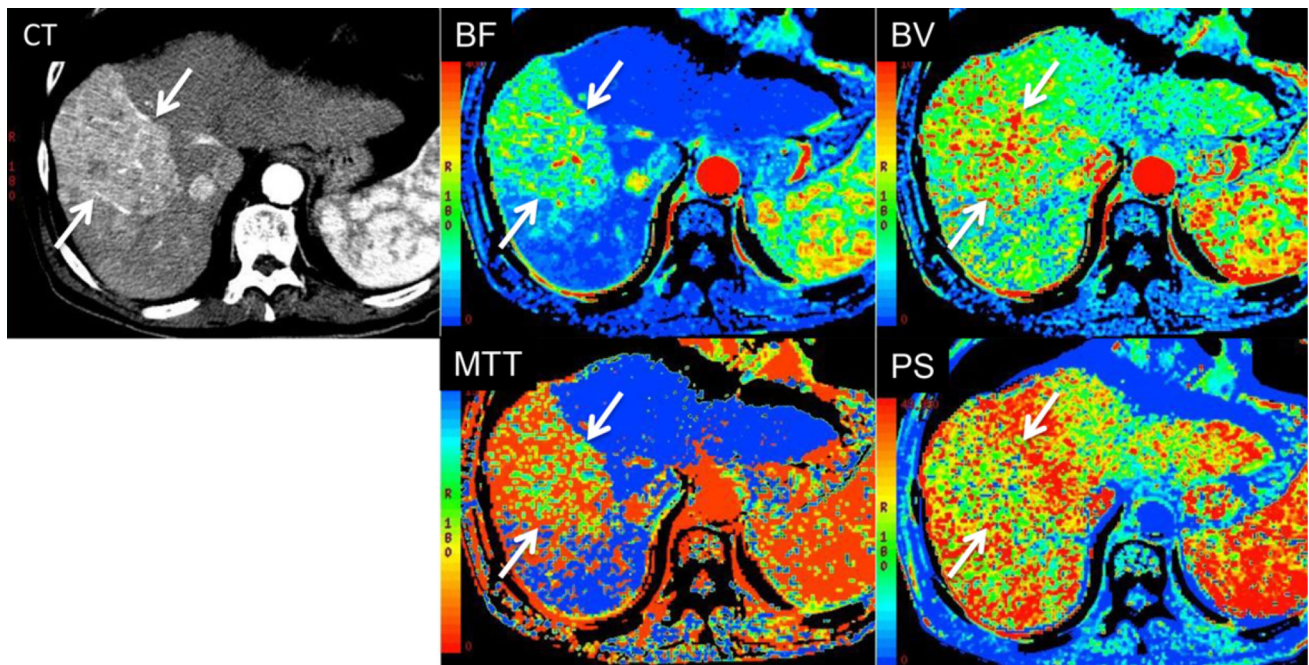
Perfusion CT of HCC. Axial CECT (CT) and respective functional maps of blood flow (BF), blood volume (BV), mean transit time (MTT), and permeability surface area product (PS) in a 79-year-old with a large hypervascular HCC (*arrows*) in the right lobe of the liver. Perfusion values from regions of interest drawn around the tumor and representative surrounding normal liver parenchyma show
